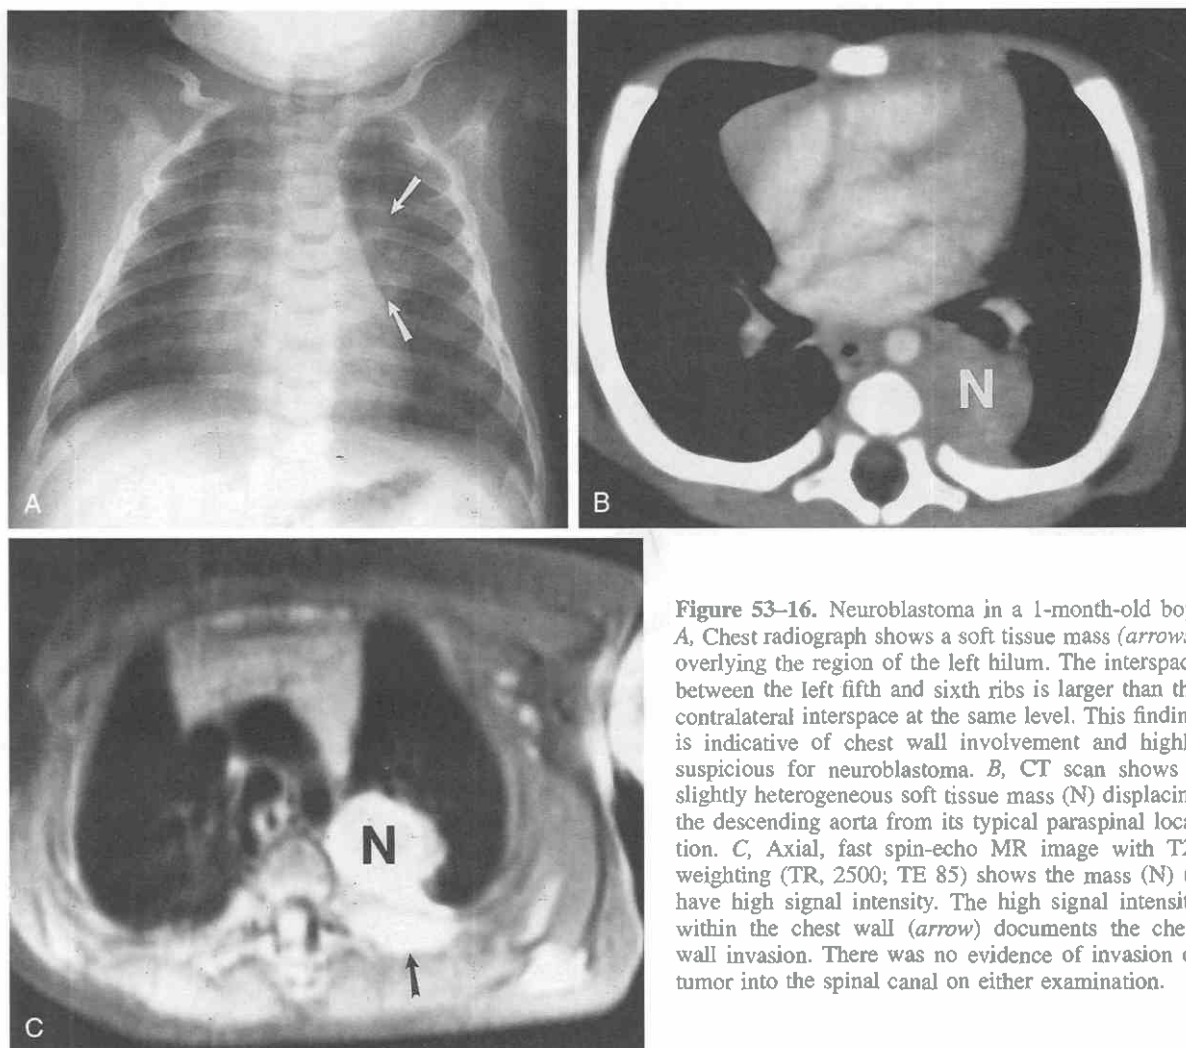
Neuroblastoma in a 1-month-old boy. *A*, Chest radiograph shows a soft tissue mass (arrows) overlying the region of the left hilum. The interspace between the left fifth and sixth ribs is larger than the contralateral interspace at the same level. This finding is indicative of chest wall involvement and highly suspicious for neuroblastoma. *B*, CT scan shows a slightly heterogeneous soft tissue mass (N) displacing the descending aorta from its typical paraspinal location. *C*, Axial, fast spin-echo MR image with T2-weighting (TR, 2500; TE 85) shows the mass (N) to have high signal intensity. The high signal intensity within the chest wall (arrow) documents the chest wall invasion. There was no evidence of invasion of tumor into the spinal canal on either examination.
